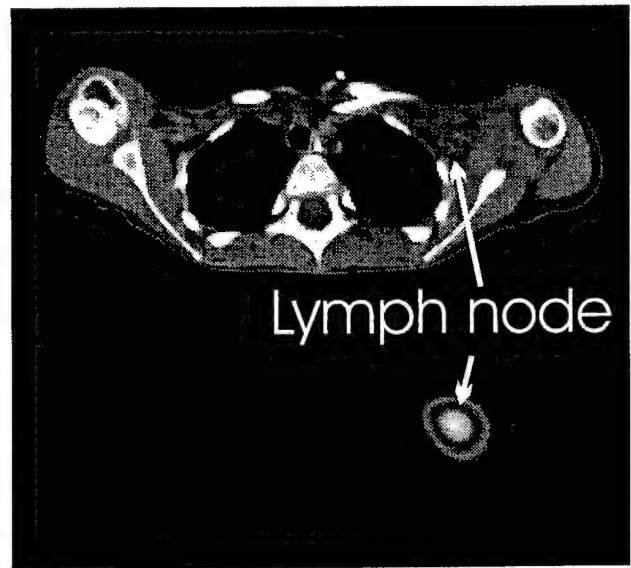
Correlated X-ray CT and  $^{131}\text{I}$ -MIBG ECT images of a neuroblastoma patient.
